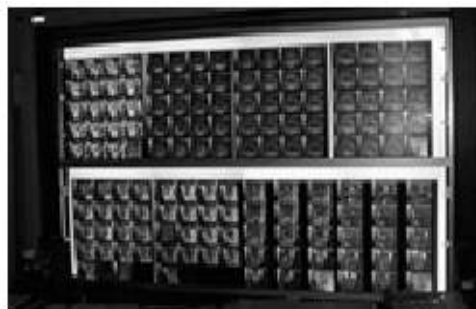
Light screen displaying MRI images.
